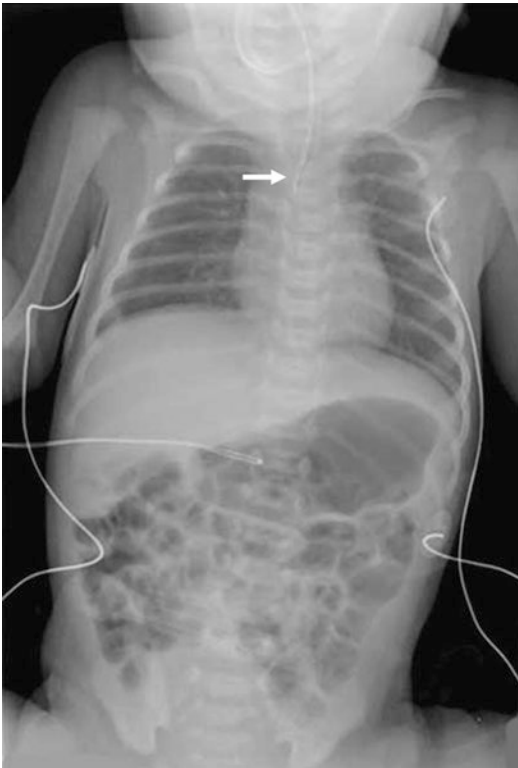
This chest radiograph shows a baby with esophageal atresia and tracheoesophageal fistula. Note the relatively low-lying proximal esophageal pouch (*arrow*). This location of the proximal esophagus would be favorable for attempting thoracoscopic repair
